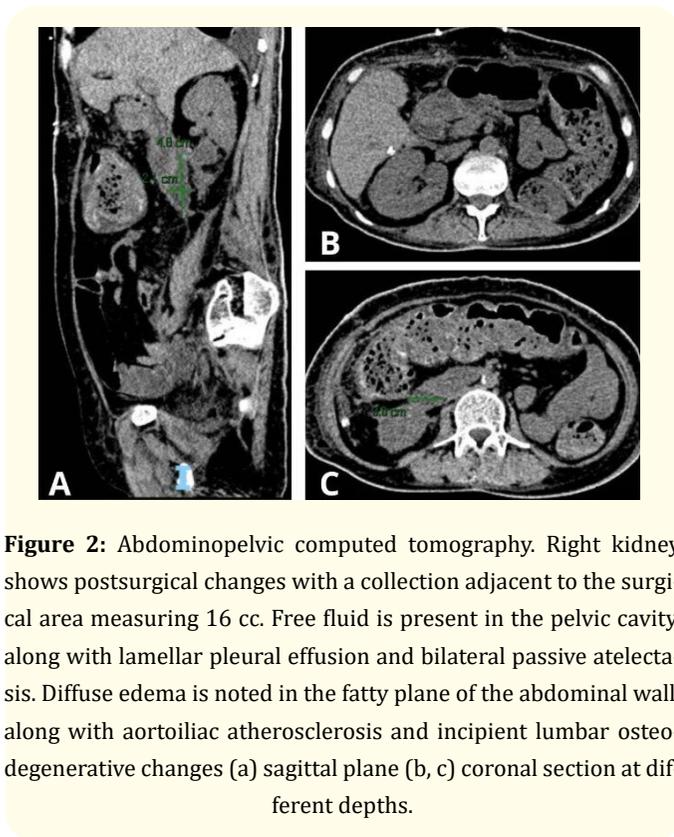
Abdominopelvic computed tomography. Right kidney shows postsurgical changes with a collection adjacent to the surgical area measuring 16 cc. Free fluid is present in the pelvic cavity, along with lamellar pleural effusion and bilateral passive atelectasis. Diffuse edema is noted in the fatty plane of the abdominal wall, along with aortoiliac atherosclerosis and incipient lumbar osteodegenerative changes (a) sagittal plane (b, c) coronal section at different depths.
